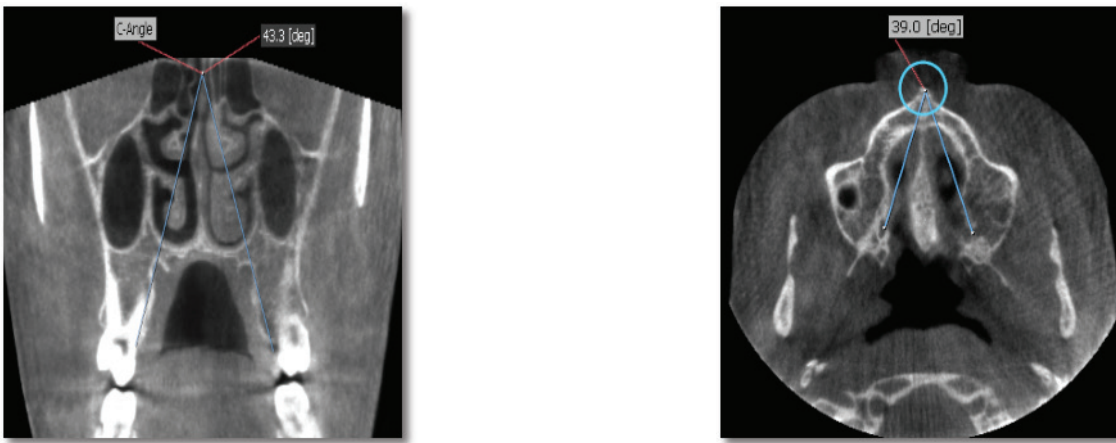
CBCT of axial and coronal cuts representing A&C angles respectively.
